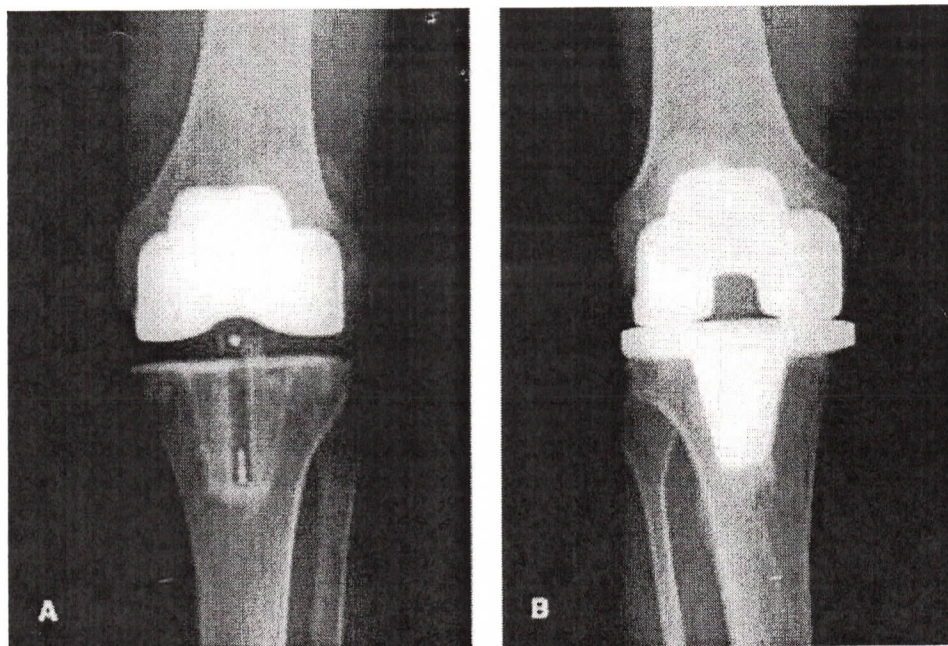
(A) Anteroposterior radiograph of the knee implanted with an all-polyethylene, cruciate-retaining tibial component at the 5-year follow-up. A radiolucent line of 1 mm is visible on the medial plateau (zones 1 and 2). (B) Anteroposterior radiograph of the knee implanted with a metal-backed, posterior-stabilized tibial component at the 5-year follow-up. A radiolucent line of 1 mm is visible on the medial plateau (zones 1 and 2).
